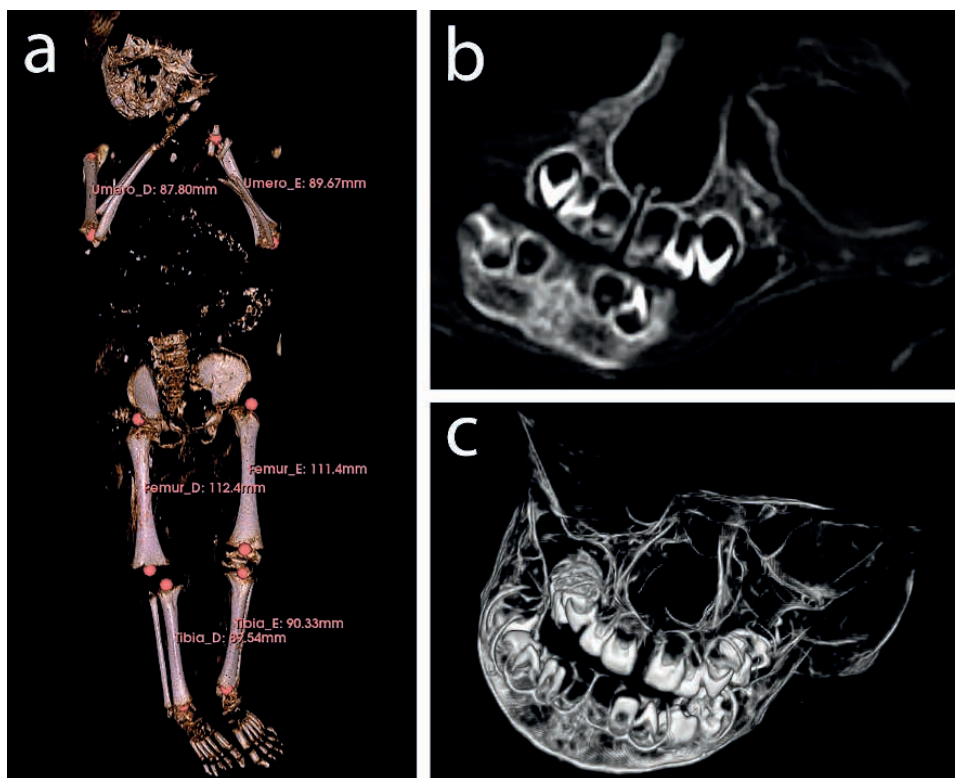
(a) Three-dimensional (3D) reconstruction of the infant's skeletal structure and specially the well-preserved long bones, and their length measurements. Notice the missing bones, such as some phalanges of the right toes, most of the ribs and vertebrae. The flexed arms with hands placed on the chest is typical of a catholic burial; (b) CT slice image of the preserved face of the same infant show mandible and maxilla bones, besides the stage of development of the dentition. (c) Three-dimensional (3D) reconstruction of the infant's face highlights dental structure confirming an age estimation between 6 and 9 months.
